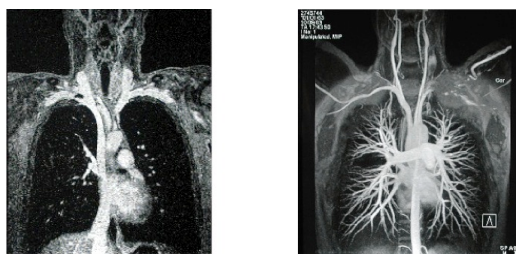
A) T1 vibre fat-sat postcontrast magnetic resonance imaging (coronal view) demonstrating the hypointense thrombus partially occluding the right-subclavian vein. B) Postcontrast flash three-dimension magnetic resonance angiography depicting mild narrowing in the right subclavian artery during hyperabduction. The left-sided “pseudoocclusion” is due to the technique (coronal oblique sequence adjusted for prompt right-sided imaging).
